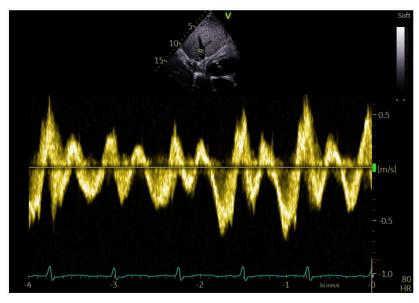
Hepatic Vein Doppler showing blunting of S-wave consistent with congestion and right heart failure
